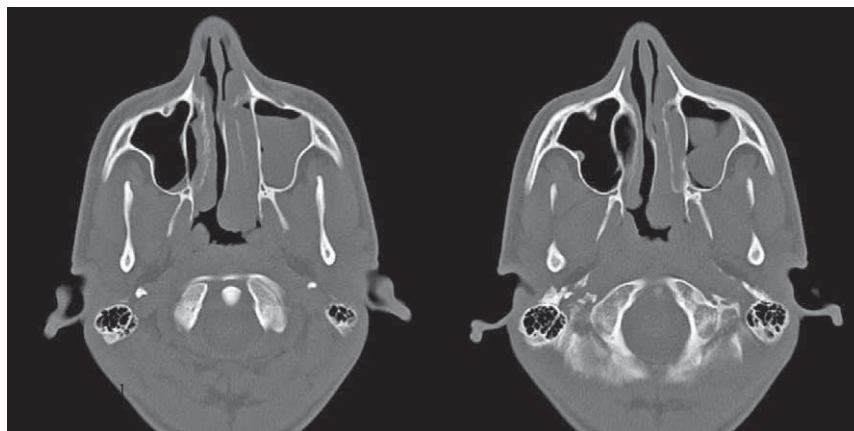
Native CT, axial slices, bone window. Soft tissue polypoid mass filling the left maxillary sinus and middle nasal meatus, following and spherically bulging into nasopharynx. The origin of the mass is a lateral side of the maxillary sinus.
